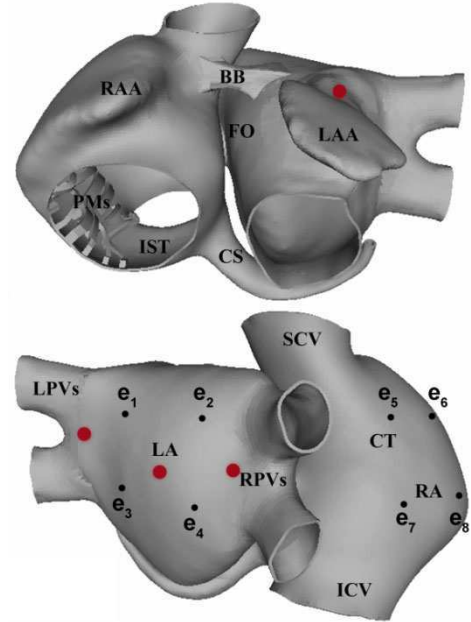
3D model of human atria, including: left (LA) and right (RA) atrial chambers, pectinate muscles (PMs), Bachmann's bundle (BB), crista terminalis (CT), fossa ovalis (FO), isthmus (IST), left (LAA) and right (RAA) appendages, coronary sinus (CS), right (RPVs) and left (LPVs) pulmonary veins, superior (SCV) and inferior (ICV) caval veins. The black dots are the eight virtual electrodes (e1 to e8). The red dots are the four different locations where the ectopic beat is applied.
